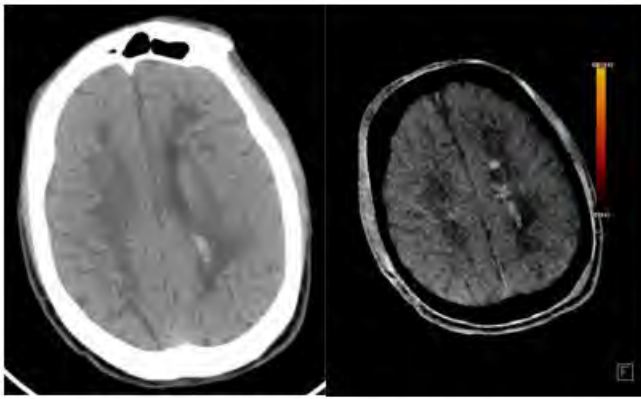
Axial noncontrast CT head with follow up dual energy virtual non-calcium map showing periventricular hemorrhage on a background of abnormal white matter.
